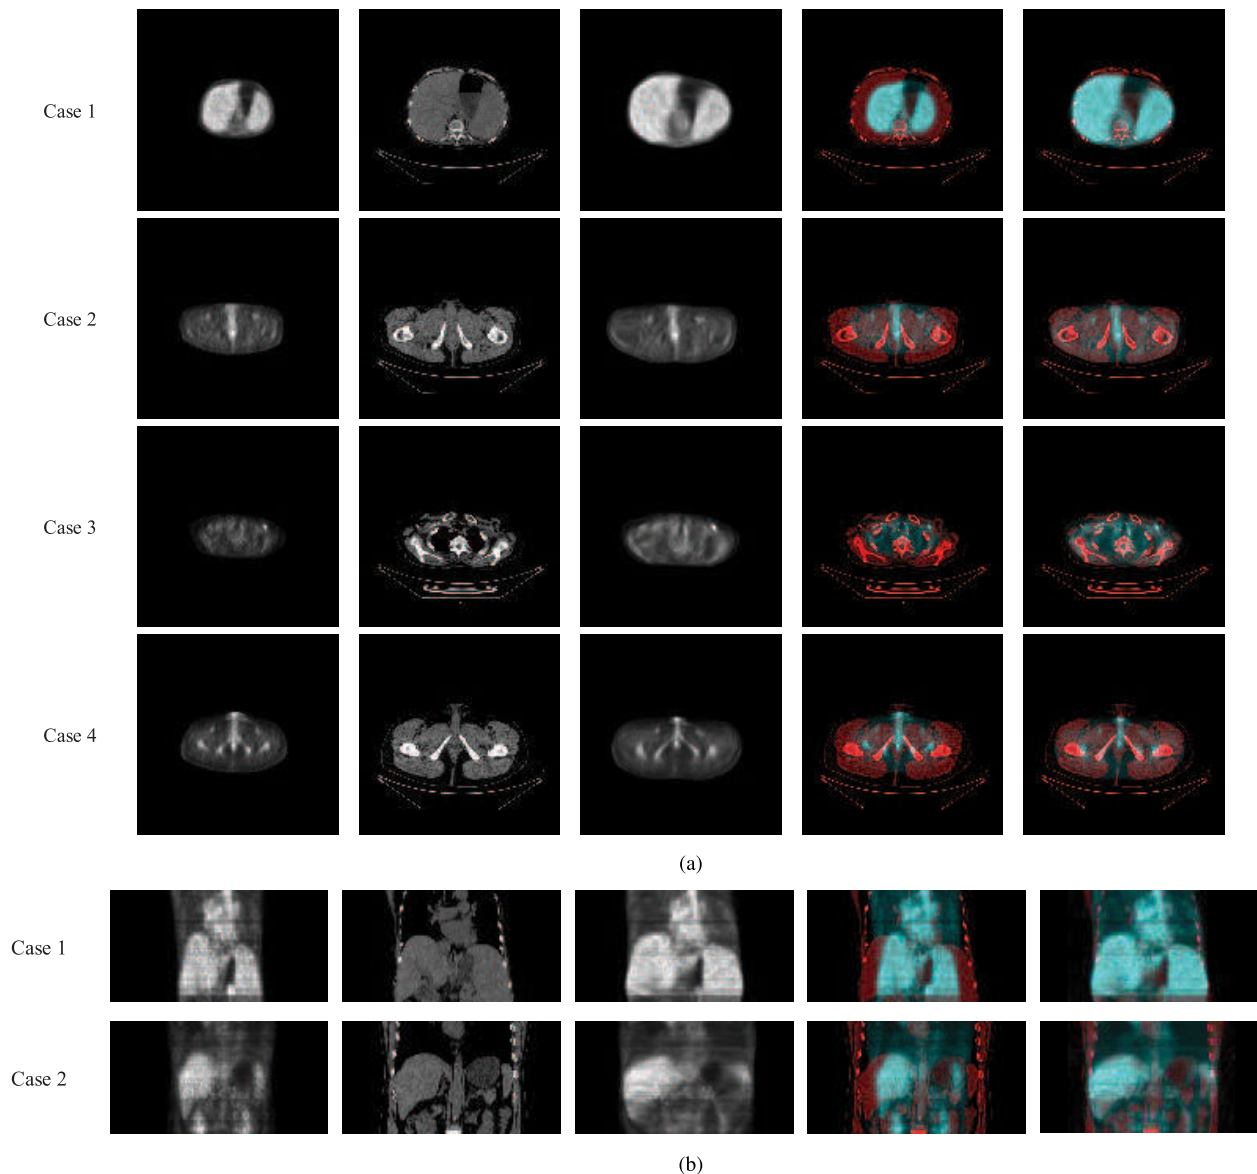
The final registration results with our proposed DenseRegNet. (a). An example of PET/CT registration results in transverse plane. (b). An example of PET/CT registration results in coronal plane. The 1 - 5th column from left to right are corresponded to the source PET image, the source CT image, the registration result, the fusion image of the source PET/CT image and the fusion image of the registered PET/CT image respectively.
